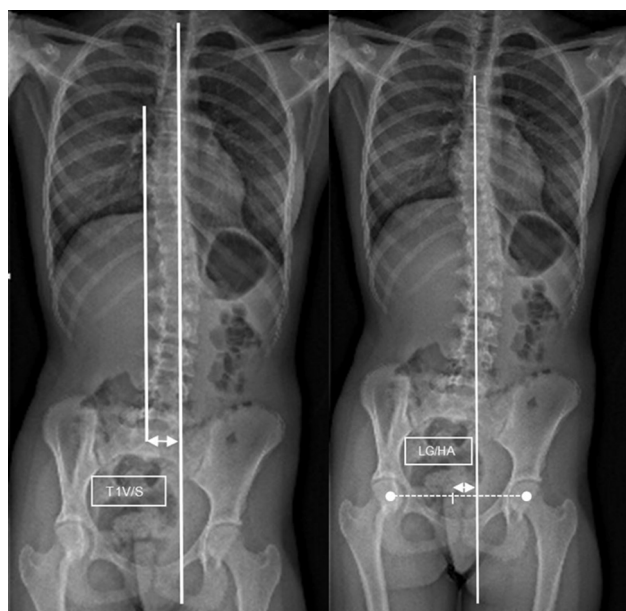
Plumb line position (T1V/S) and gravity line position (GL/HA). T1V/S, distance between the vertical through the middle of T1 and the midpoint of the S1 endplate; GL, gravity line localised using biplanar radiographs; HA, midpoint of the line connecting the femoral heads; GL/HA, distance between the gravity line and HA.
